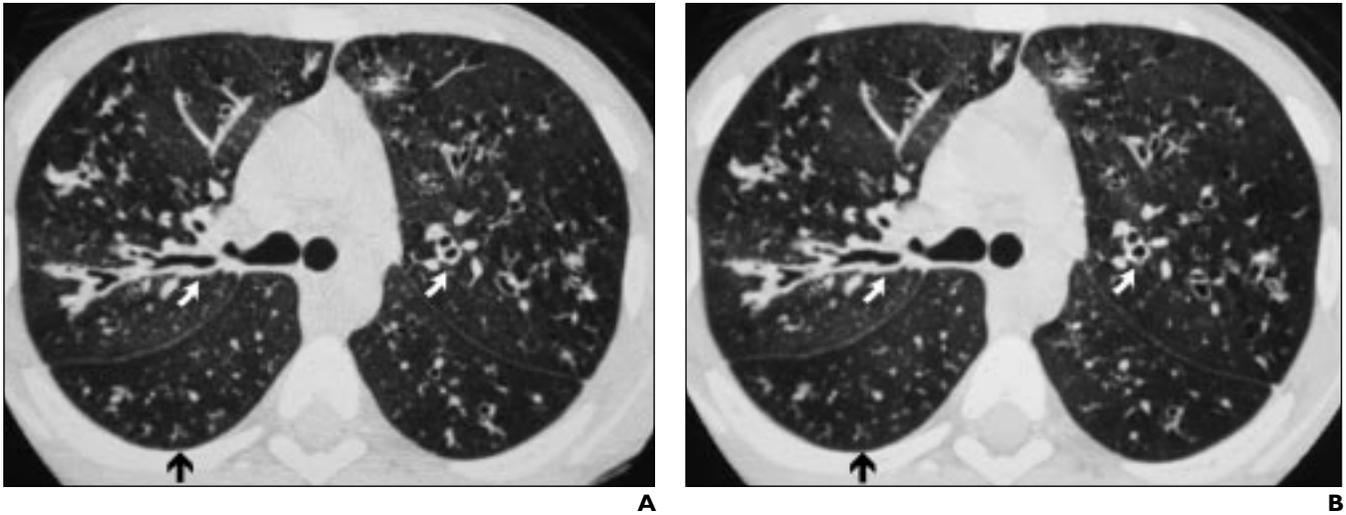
12-year-old boy with cystic fibrosis. A and B, High-resolution CT scans of chest obtained with 34 mAs (A) (image quality average score, 4.40) and 180 mAs (B) (average image quality score, 4.33) show peribronchovascular thickening (*curved arrows*), bronchiectasis, and tree-in-bud appearance of peripheral bronchi (*straight arrows*).
